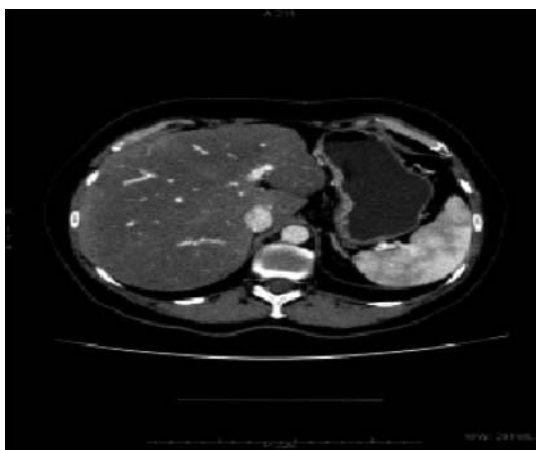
CT. Liver metastasis of SBC in segment 4 – post - chemotherapy. Complete remission
